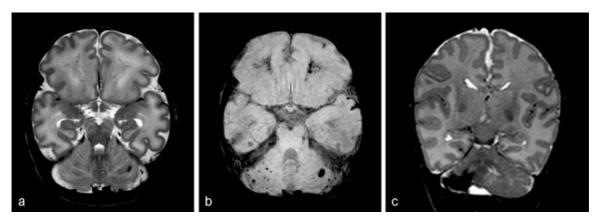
(a and b) Punctate hemorrhagic cerebellar lesions, not recognized with mastoid window cranial ultrasound and more clearly seen with the (b) susceptibility-weighted imaging sequence than the (a) T2-weighted axial magnetic resonance imaging. Also note bilateral punctate lesions in the frontal white matter. (c) A larger cerebellar hemorrhage is shown in another infant with atrophy of the cerebellar hemisphere at termequivalent age.
